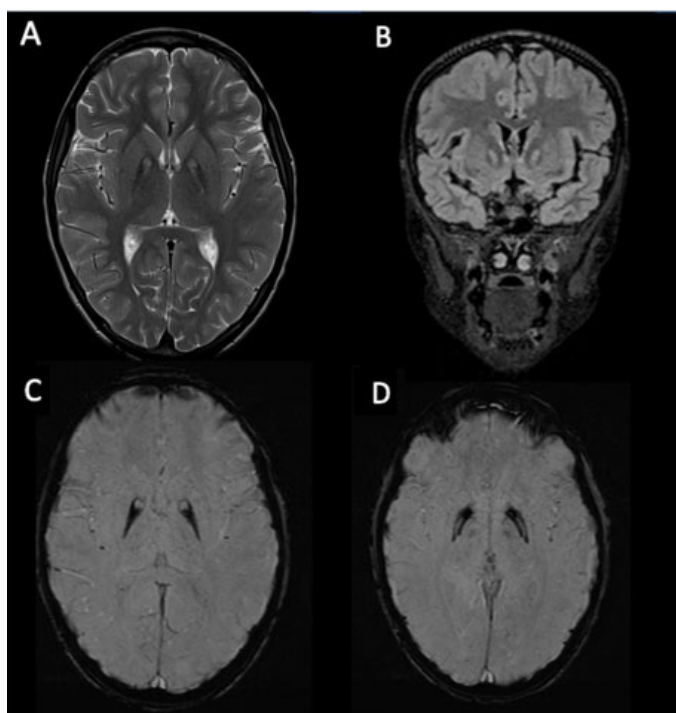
(A) Brain MRI axial sequence in T2-weighted, (B) coronal sequence in FLAIR, (C and D) and axial sequences in SWI, showing bilateral aspect of “eye of the tiger” sign, with central area of hyperintensity surrounding a region of hypointensity in the globus pallidus in T2-weighted and FLAIR, and hypointensity in SWI.
